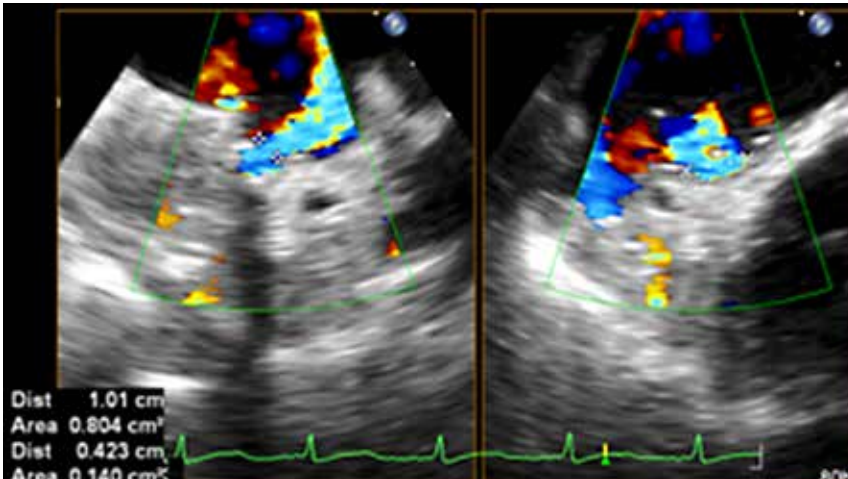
Preoperative two-dimensional transesophageal echocardiography (TEE), color biplane imaging: a moderate oval shaped paravalvular leak (PVL), 1.01 × 0.42 cm in size, was detected.
